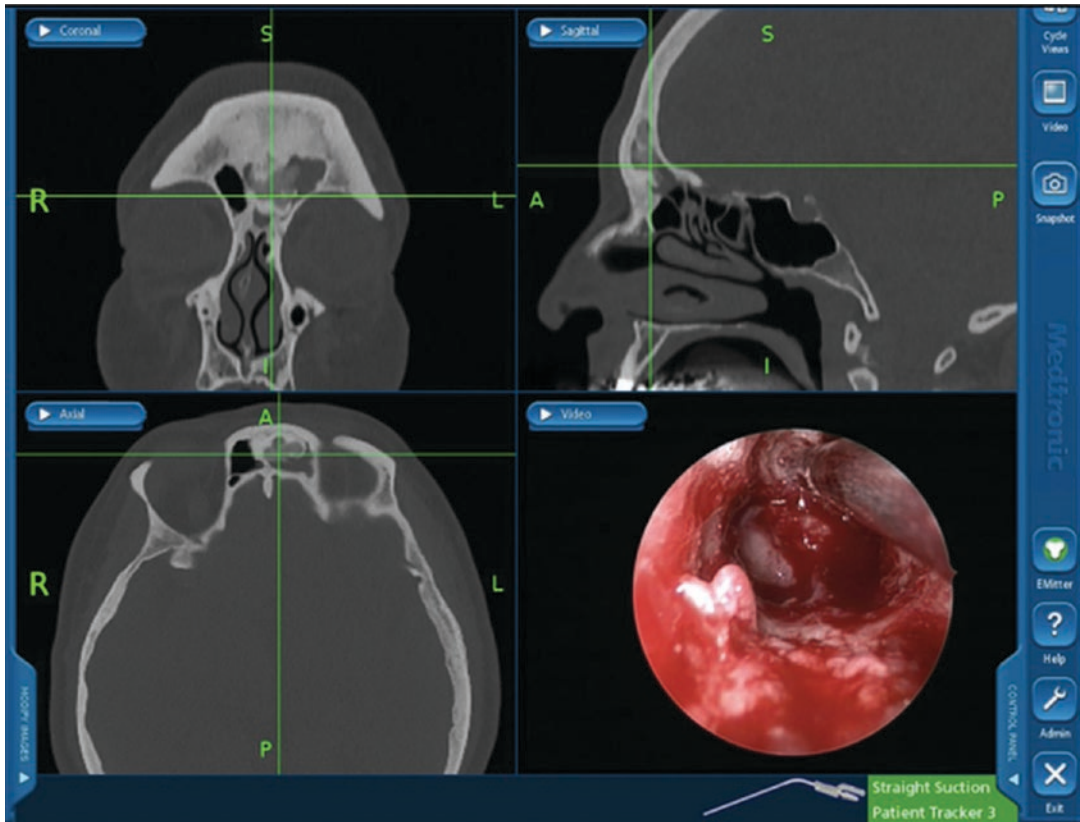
An “outside-in” Draf III procedure being performed for a left-sided frontal osteoma with the help of CT image navigation using the Medtronic fusion navigation system (Minneapolis, MN, USA)
